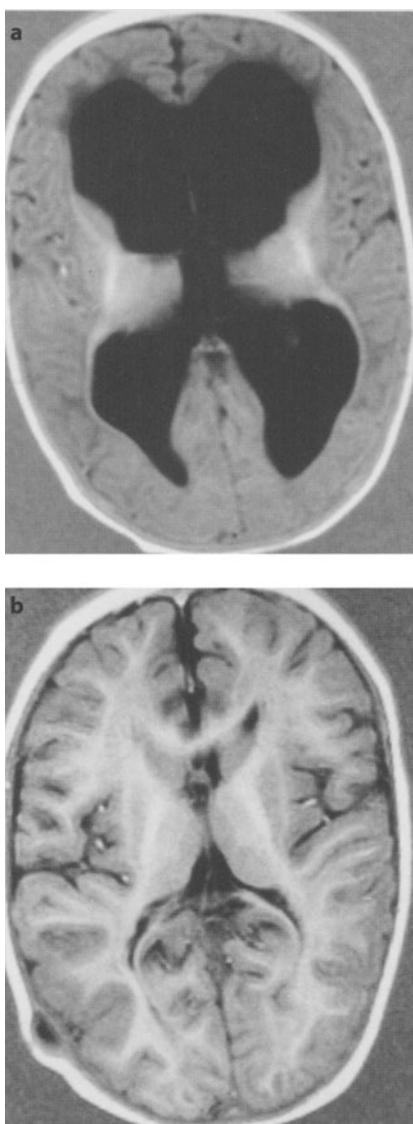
Myelination on MRI (inversion recovery) in shunted hydrocephalus: a preoperative myelination of 56% (percentage of normal for age); b 6 months postoperative myelination of 95%
